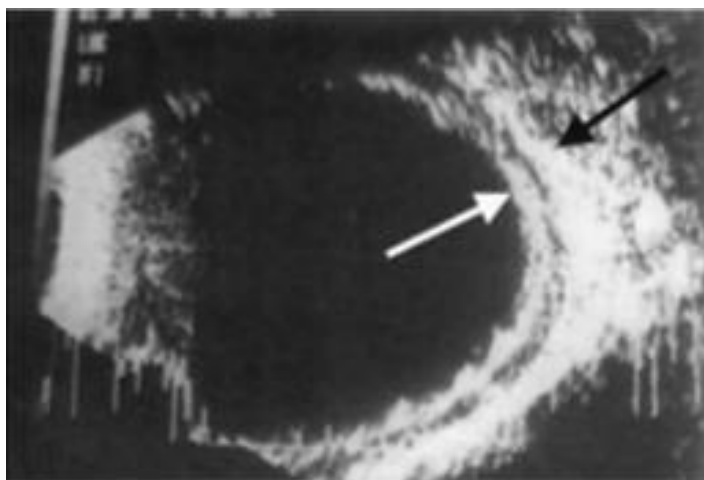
Orbital ultrasound: “double wall” sign specific of giant orbital hydatid cyst.
